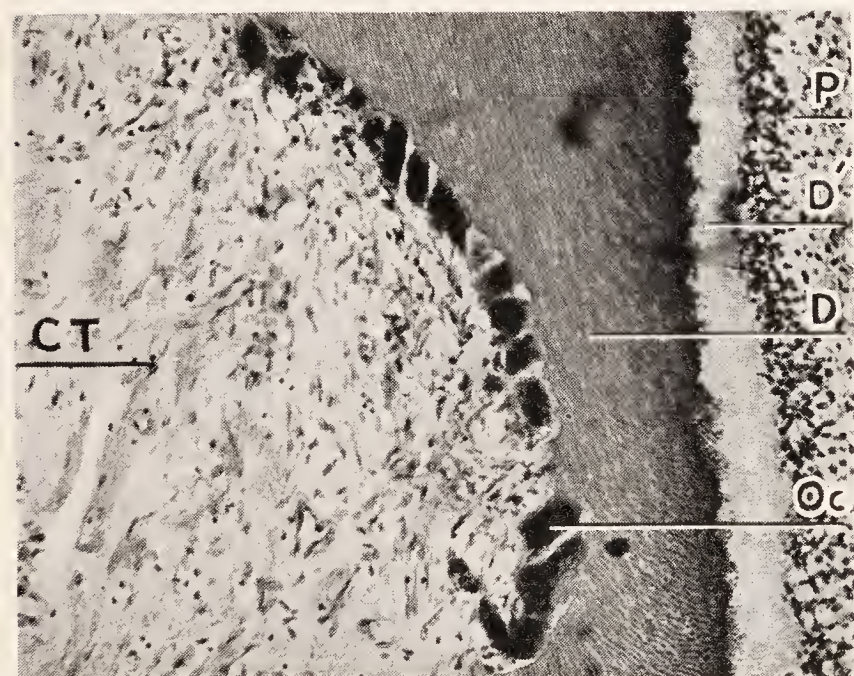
Higher magnification of the dentin resorption in Fig. 213. The entire dentin surface is densely beset with polynuclear osteoclasts (giant cells). P, pulp; D', dentinoid; D, dentin; Oc, osteoclasts lying in Howship's lacunæ in the dentin; CT, connective tissue. (Mueller, Jour. Am. Dent. Assn.)
